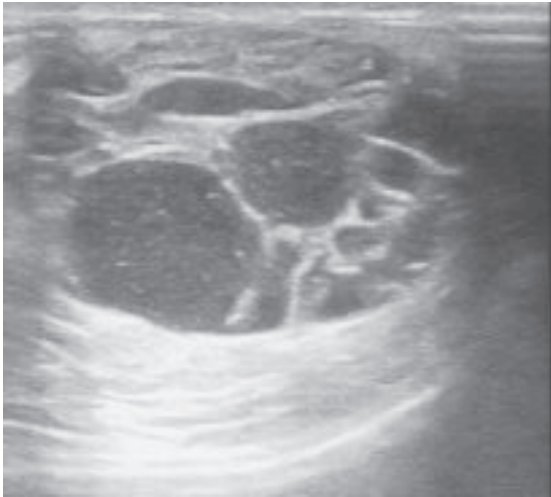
Grey scale sonogram findings of Hydatid Cyst.
